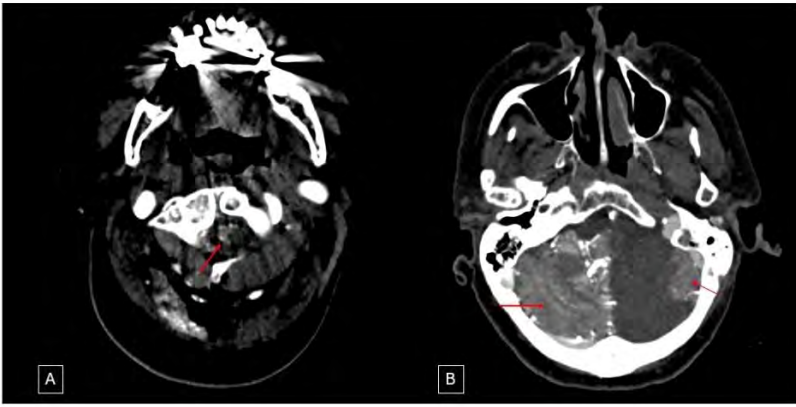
Axial CT Angiogram following intra-arterial contrast injection demonstrating enhancement in following areas: right cervical hemicord (A), entire right cerebellum/medulla and contralateral superolateral cerebellum, sparing left medial cerebellum/left half of medulla (B), right pons and bilateral occipital lobes (C), entire midbrain, bilateral thalami and paramedian parietal lobes (D,E).
